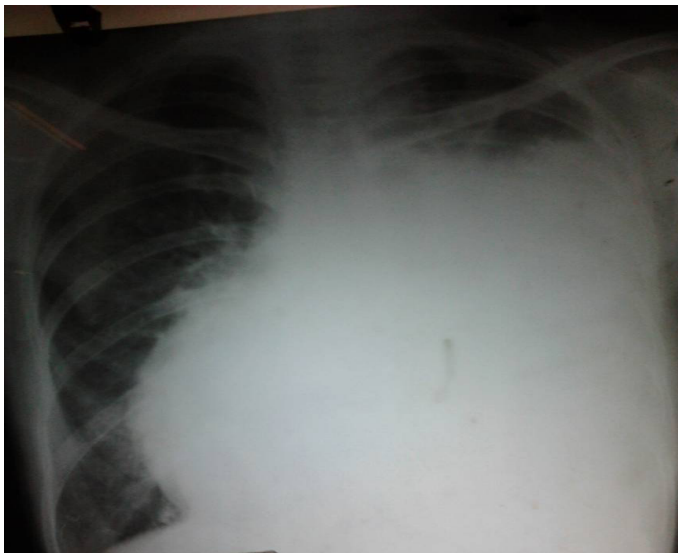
Chest x-ray mimicking pleural effusion.
